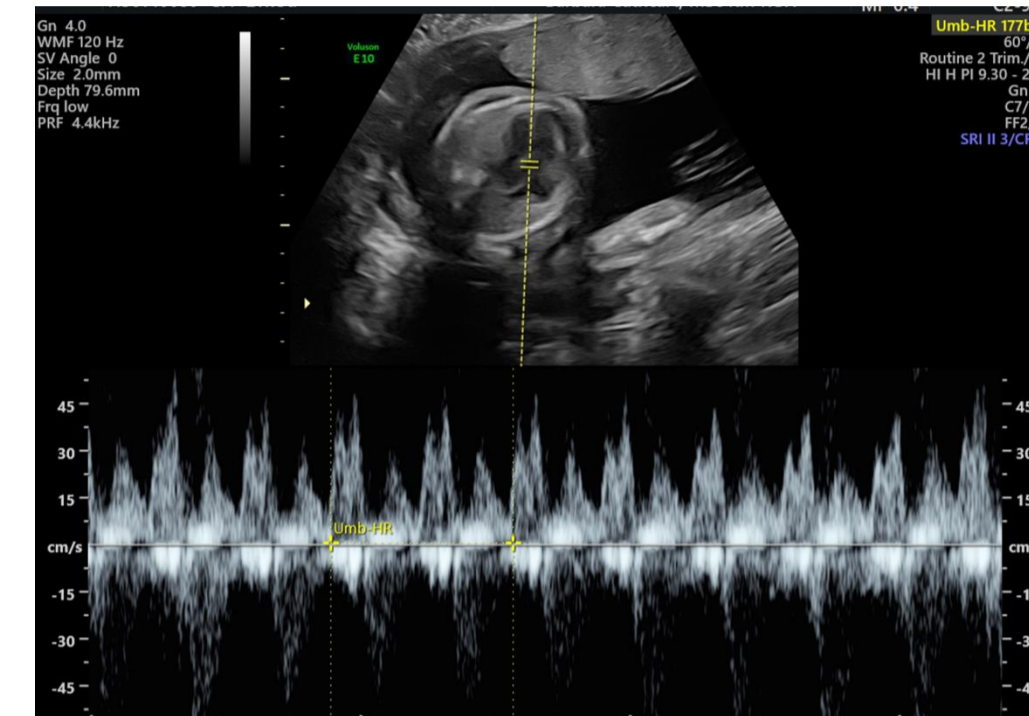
Doppler study showing fetal tachycardia 177bpm
